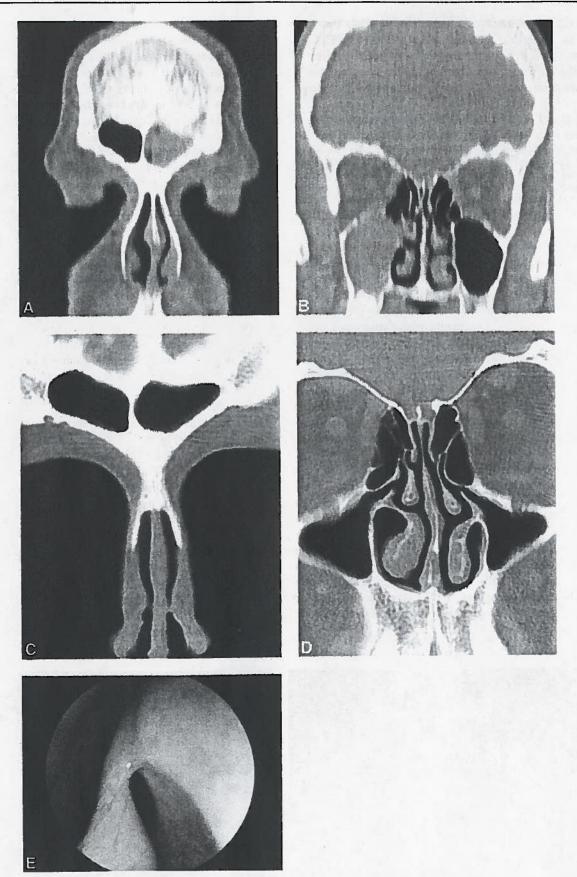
Case example of 38 year old female with chronically opacified frontal and maxillary sinuses, which have remained ventilated two years after balloon dilation. (A) Preoperative CT of opacified left frontal sinus. (B) Preoperative CT of opacified right maxillary sinus. (C) Two-year-postoperative CT of left frontal sinus after balloon dilation, comparable to (A). (D) Two-year-postoperative CT of right maxillary sinus after balloon dilation, comparable to (B). (E) Left frontal drainage pathway, two years after balloon dilation.
